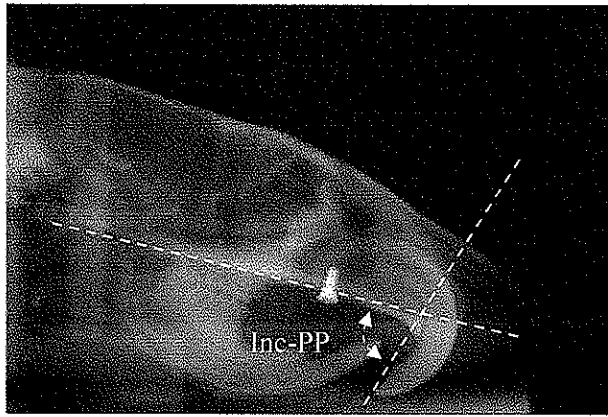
The angle between the palatal plane and the lingual surface of the maxillary incisors (Inc-PP) was measured on the lateral radiographs.
